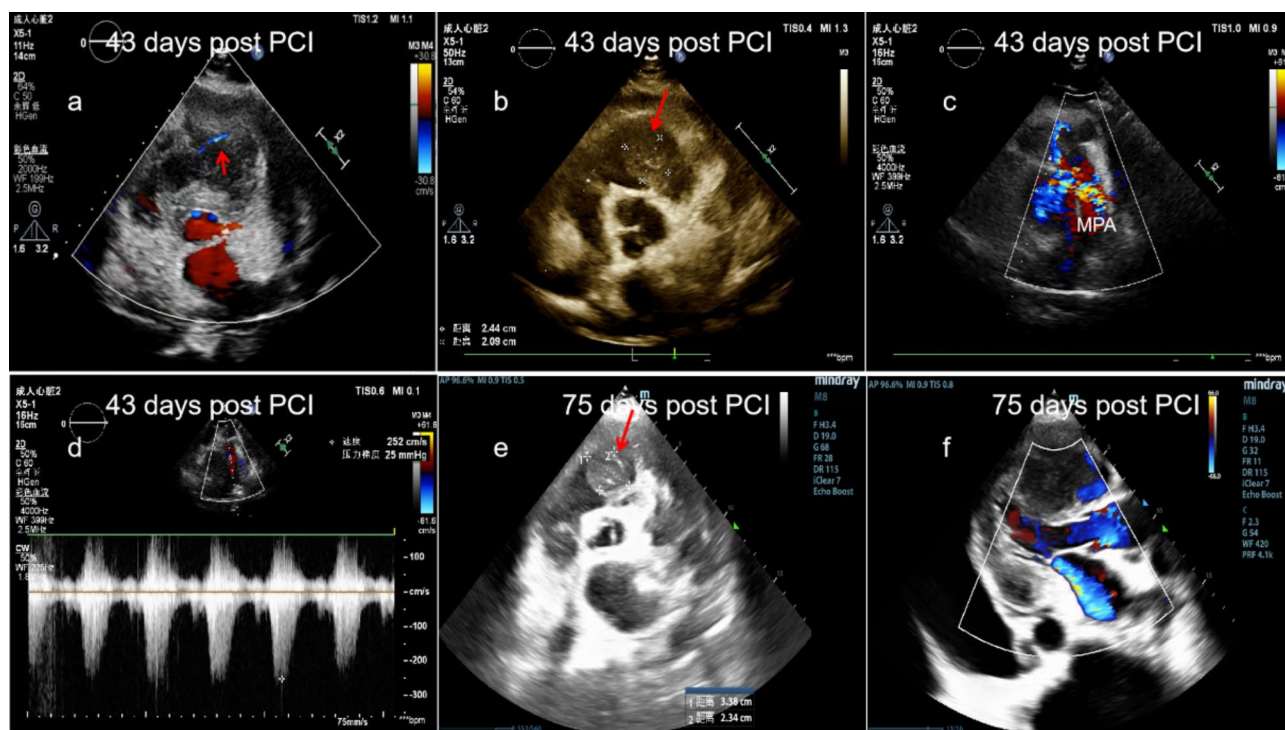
a, b, At 43 days post PCI, the RVOT mass (red arrow) measuring approximately 24×21 mm was connected to the middle segment of the anterior septum surface with minimal color flow signal at their junction observed on color Doppler imaging (red short arrow). c, d, The mass caused an increase in forward velocity across the pulmonary valve resulting in a flow rate of 2.5 m/s and pressure differential of 25 mmHg. e, f, At 75 days post PCI, TTE image showing an increase in mass (red arrow) within the RVOT (approximately measuring 34×23 mm), moderate mitral regurgitation, and minimal pericardial effusion. MPA, main pulmonary artery
